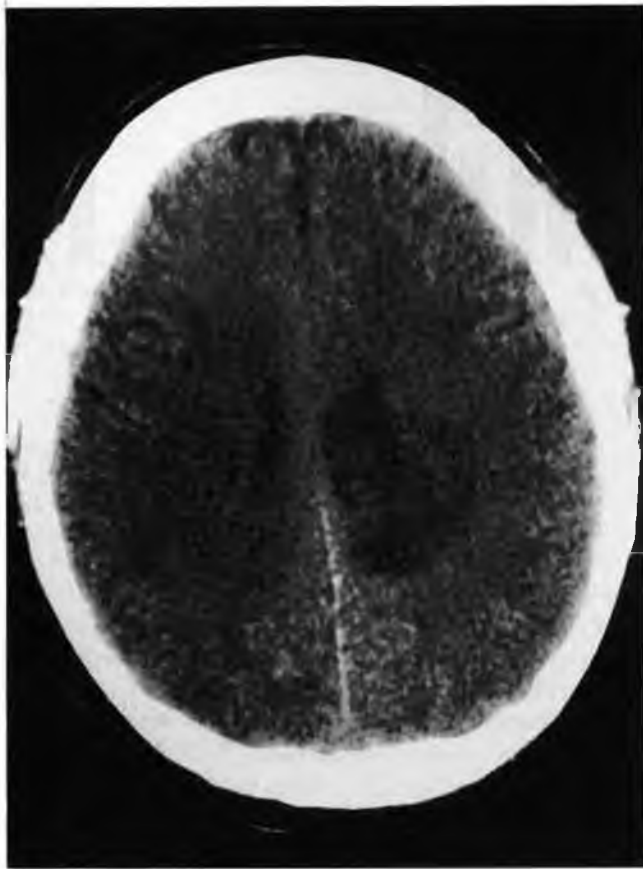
CT of the brain of a typical patient with aspergillus brain abscess. A large hypodense lesion is evident in the parieto-temporal region.
